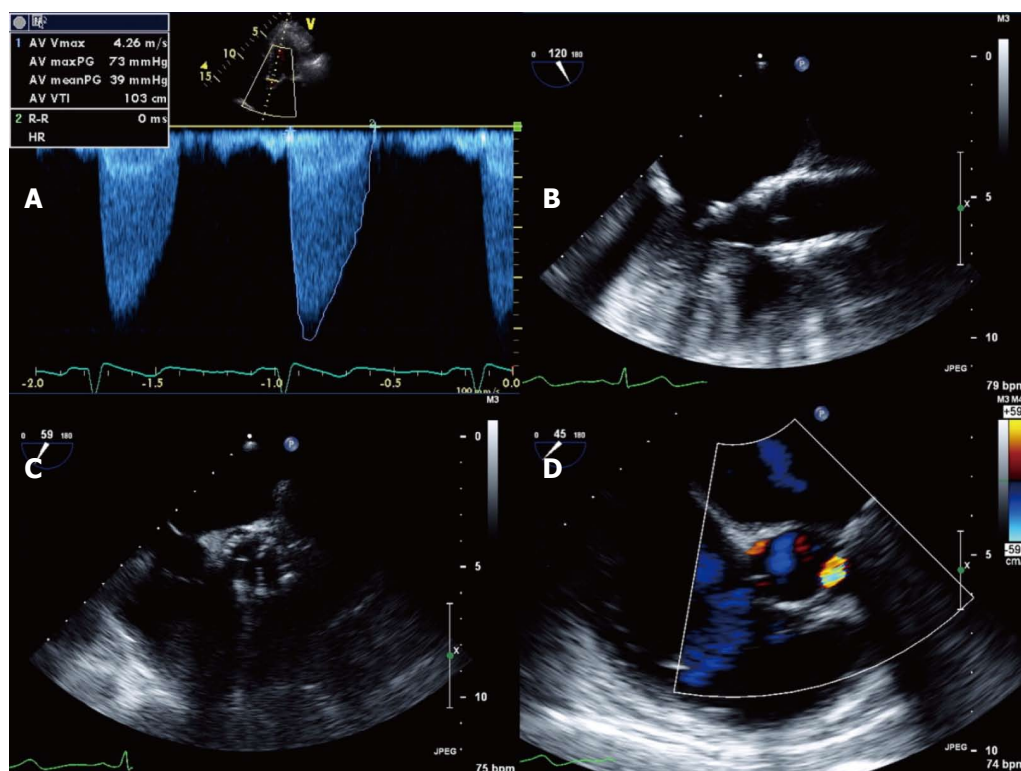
Transesophageal echocardiogram. It shows transprosthetic gradients compatible with severe aortic stenosis (A); Absence of obvious mass or valve thrombosis on Transesophageal echocardiogram (B, C) but moderate paravalvular leak (D).
